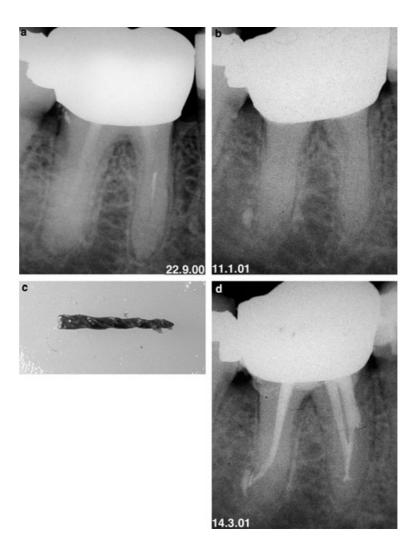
(a) Fractured instrument (GT Rotary 20.06T) in mesiobuccal canal of a mandibular right first molar. (b) Instrument removed using ultrasonically activated file. Removal time: 45 min. (c) Instrument fragment. (d) Root canal obturation after successful removal of the instrument: significant ledge formation is evident.
